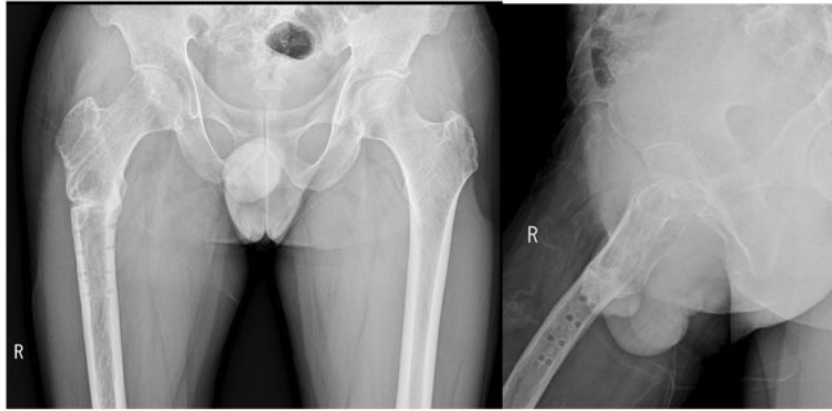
Solid bony union on 2-year post-operative X-ray films.
